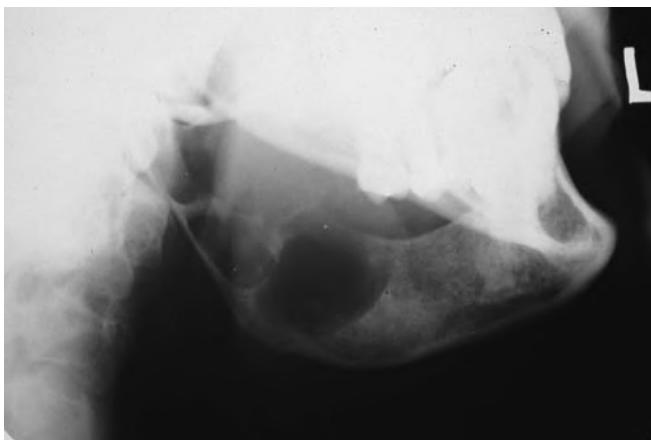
A lateral jaw radiograph of a patient with an ameloblastoma, which caused swelling of the jaw. (Courtesy Dr. Axel Ruprecht.)
